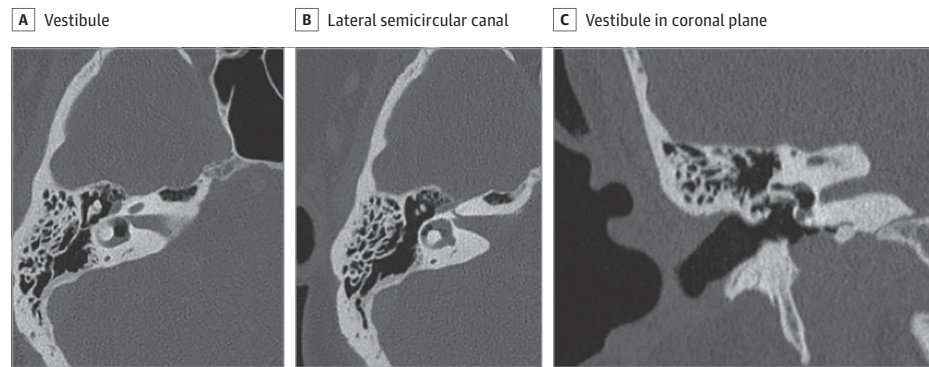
Axial computed tomography image of the temporal bone showing air in the right inner ear, specifically, the vestibule (A) and lateral semicircular canal (B). Air also visualized in the vestibule in the coronal plane (C).
